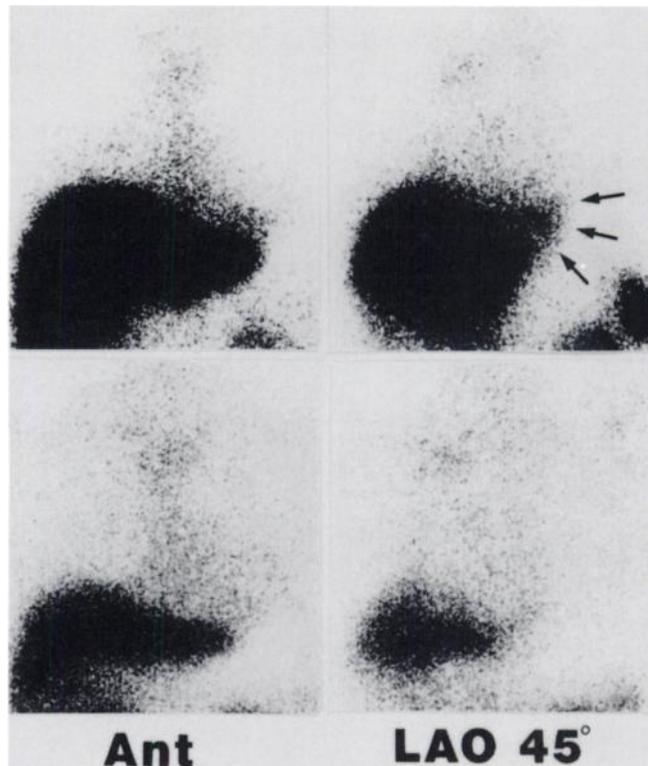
Planar ^{111}In -antimyosin scintigraphic images obtained at 3 days after the onset of MI (upper images) and 1 yr later (lower images). Definite inferior myocardial uptake is seen right above the liver in the first study (arrows, HLR, 2.34), while no uptake can be seen in the second (HLR, 1.23).
